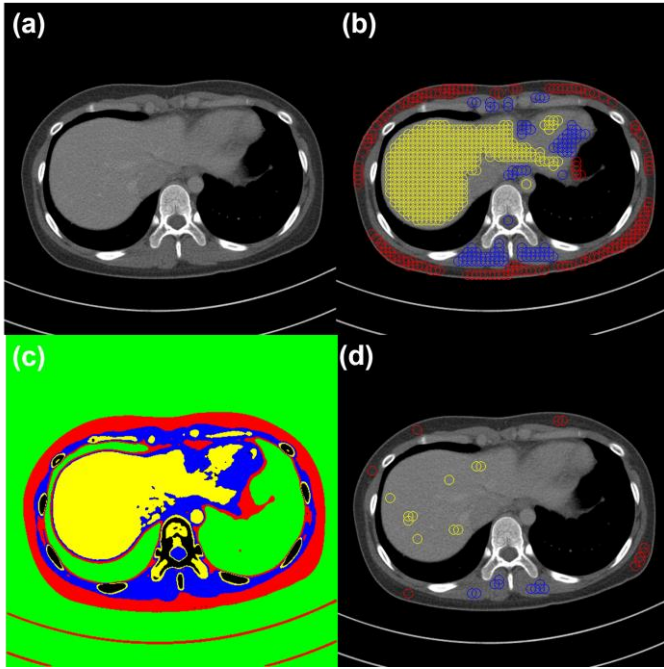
(a) Example CT image, (b) initial candidate ROIs on predefined ranges, (c) tissue-specific initial mask, (d) selected top 10 homogeneous ROIs; fat with red circle, muscle with blue circle, and liver with yellow circle.
